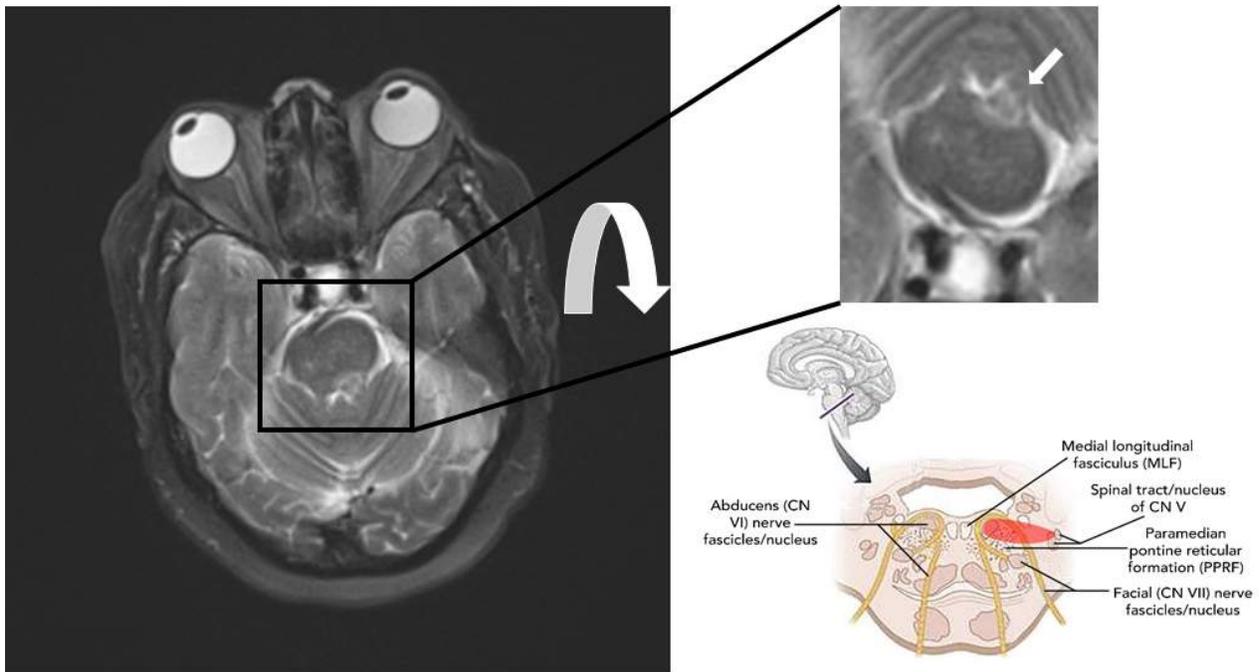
MRI Brain T2 Axial demonstrating left dorsal pontine hemorrhage with comparison brainstem anatomy figure highlighting correspondence of MRI hyperintensity (white arrow) with known locations of CN 5, CN 6 and CN 7. Redrawn with permission from Dr. Timothy Martin, MD.
